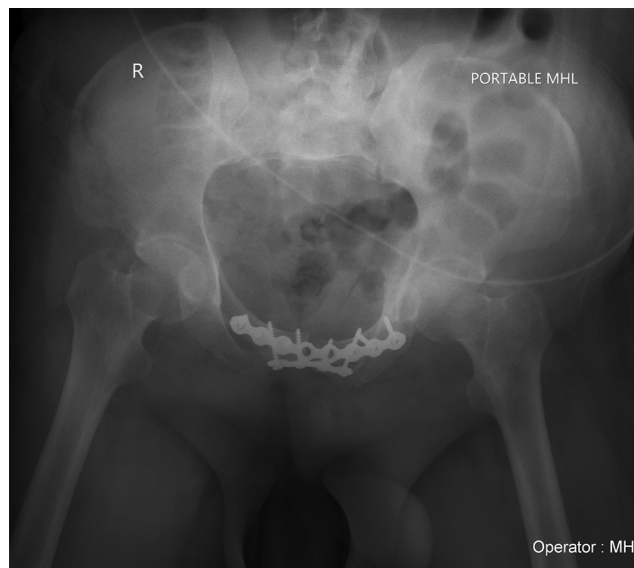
Antero-posterior radiographs after anterior stabilization of pelvis.
